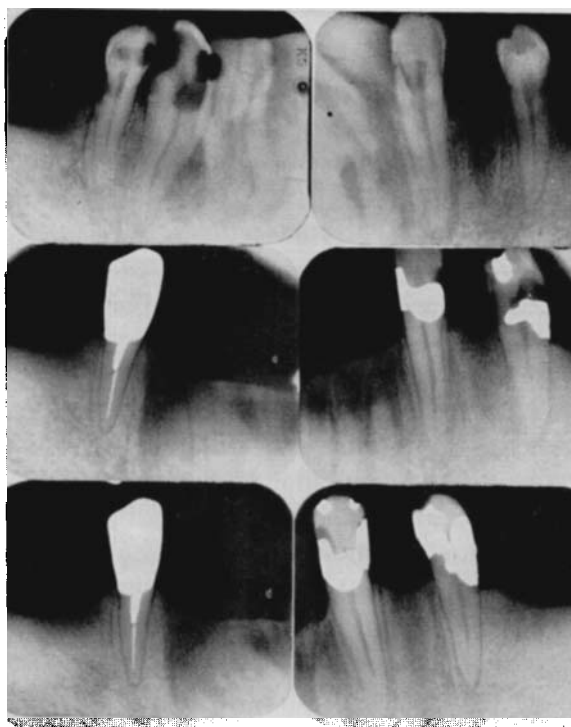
X-ray pictures of remaining teeth in a lower denture case classified as Kennedy I². The right lower first bicuspid and the left lower cuspid and second bicuspid are used as abutments and all other lower teeth (top picture) were extracted before denture treatment. A comparison of the marginal bone condition at the one-year and the four years controls shows no bone deterioration. At the clinical evaluation these teeth were not considered mobile. Frequent carious lesions have appeared during the observation period. (Note the fairly translucent area at the region for the right lower cuspid even four years after its extraction).
